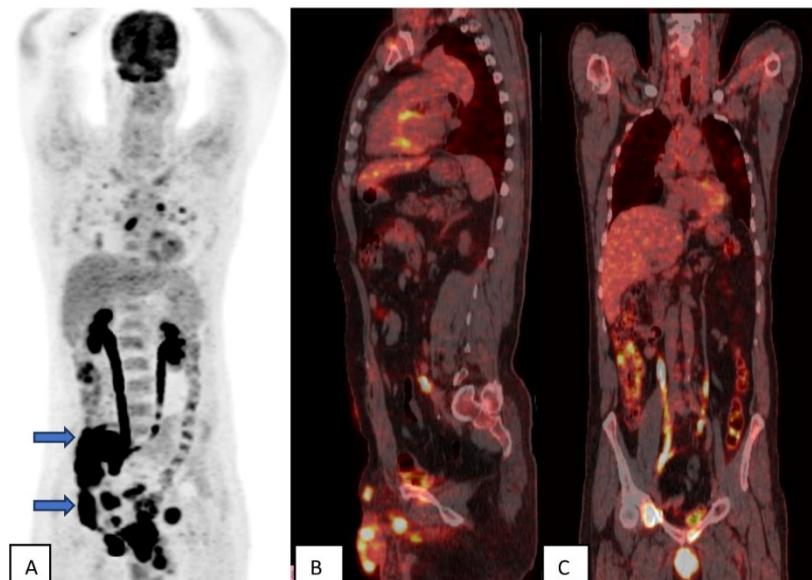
Positron emission tomography/computed tomography with $[^{18}\text{F}]$ FDG, (A) MIP, (B) sagittal fusion and (C) frontal fusion images showing multiple hypermetabolic foci in the penile, the inguinal region, and in bilateral pulmonary nodules. Intense activity was noted in the neobladder (upper straight arrow) and the urine bag (lower straight arrow)
